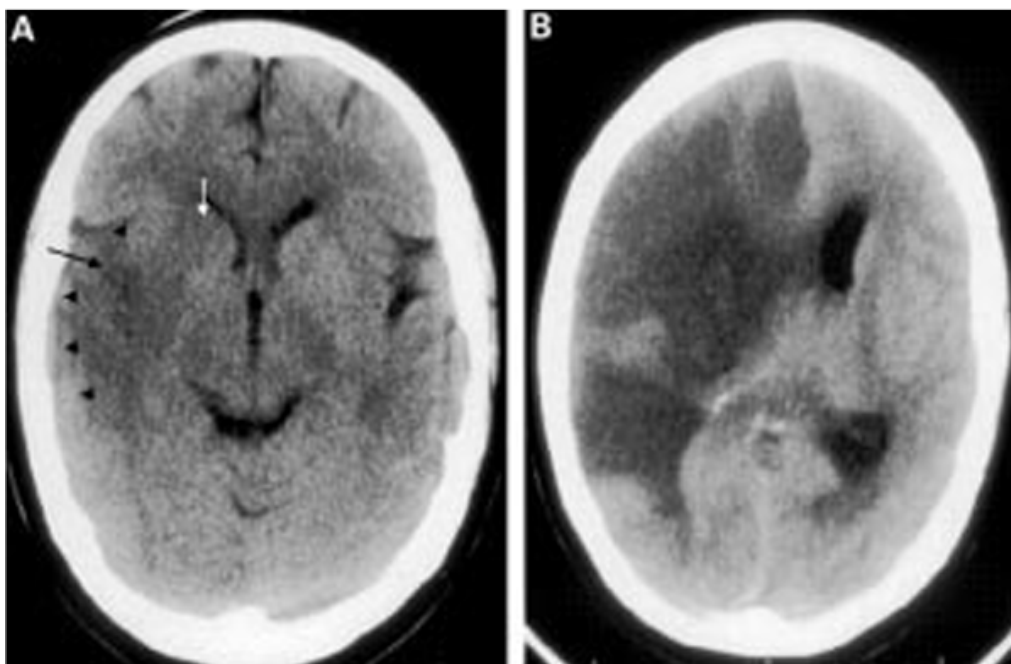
CT brain scan showing a right hemisphere total anterior circulation infarct (A) at four hours, and (B) at five days after symptom onset. Note on (A) the subtle signs of early infarction: loss of the basal ganglia on the right (white arrow) compare with the left where the caudate and lentiform nuclei are clearly visible), loss of the grey/white matter cortical differentiation (black arrowheads), a little swelling with sulcal effacement (black arrow and compare left side). On day 5 there is obvious hypodensity and massive infarct swelling with midline shift and obstruction of the left lateral ventricle.
